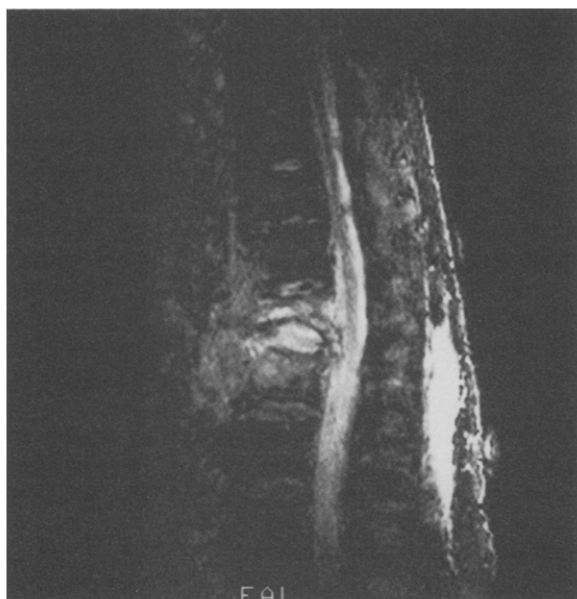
MRI of T12 and L1 vertebrae shows bony destruction of anterior bodies by infectious process.
